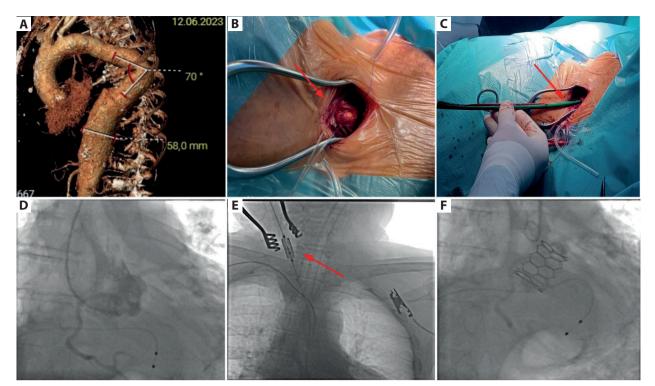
A. Computed tomography angiography with 3D reconstruction showing acute angulation of the thoracic aorta, an abdominal aortic aneurysm, however with the appropriate vessel size and lack of significant stenoses within the range of the right common carotid artery. B–C. Surgically exposed transcarotid access for the transcatheter aortic valve implantation procedure (red arrows). D. Arteriography before valve deployment. E. Transcarotid access — valve delivery (red arrow) and positioning. F. Successful deployment of the transcatheter heart valve
